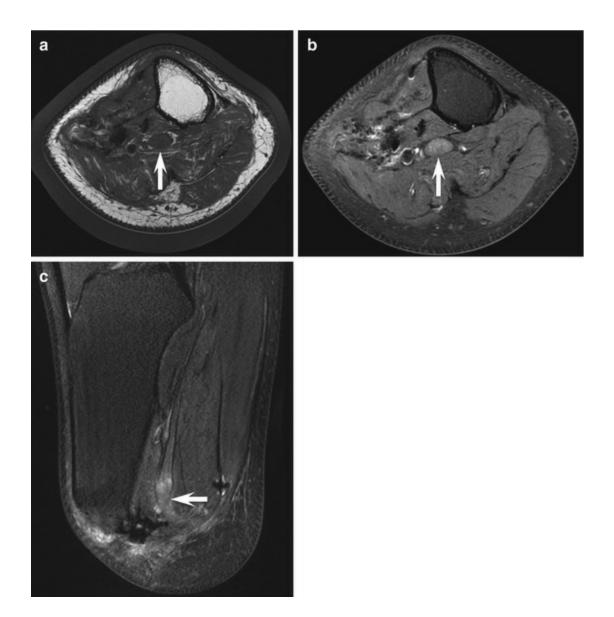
Neuroma of the posterior tibial nerve after leg amputation. Axial (a) unenhanced and (b) contrast-enhanced fat-suppressed and T1-weighted MRI show the neuroma (*arrow*). (c) Sagittal fat-suppressed T2-weighted MRI shows the neuroma covered by muscles. Note also bursitis under the lower extremity of the tibia
